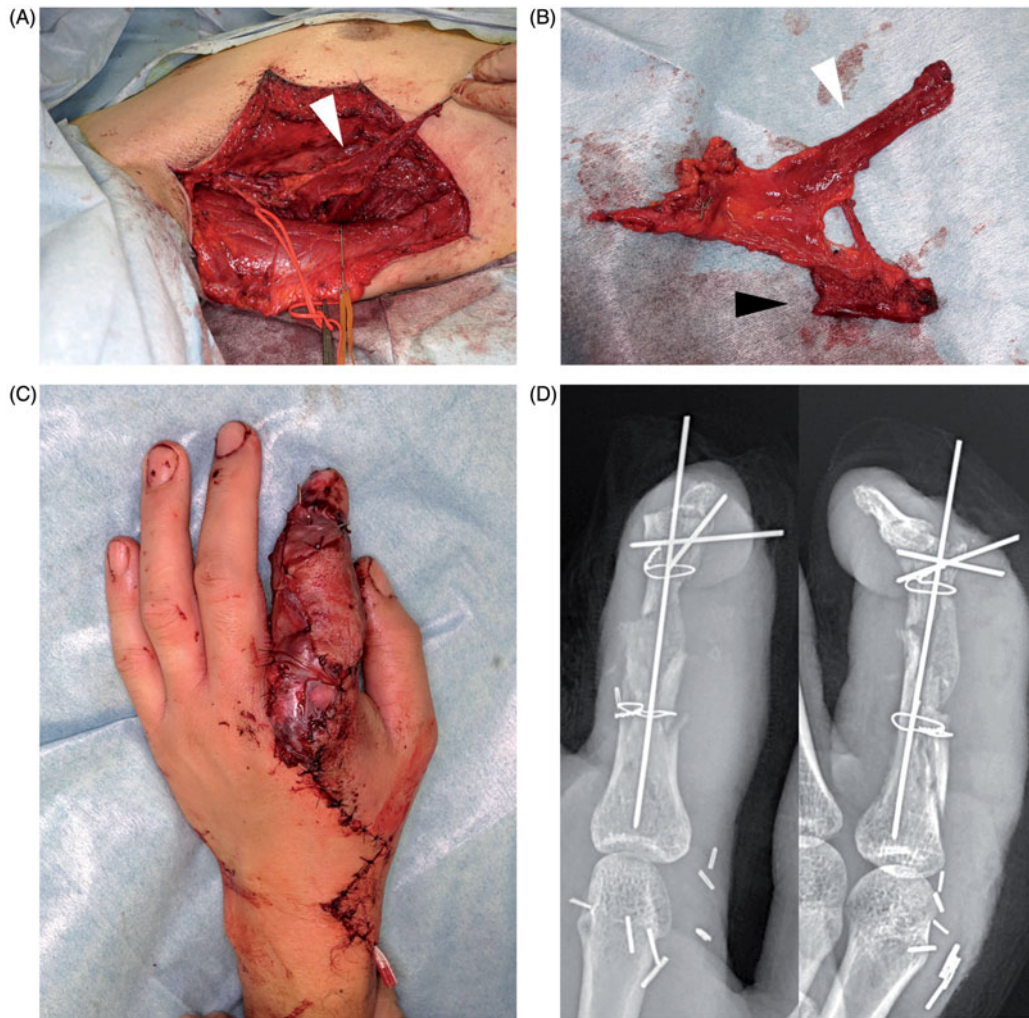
Second operation in case 2. (A) Intraoperative view of flap-harvesting procedure. White arrowhead indicates the fascial flap. (B) General view of the flap. White arrowhead indicates the fascial component, and black arrowhead indicates the bone segment. (C) Transferred flap after microsurgery with immediate split-thickness skin grafting. (D) X-ray showing skeletal reconstruction of the index finger with vascularized bone grafting fixed with surgical wire.
